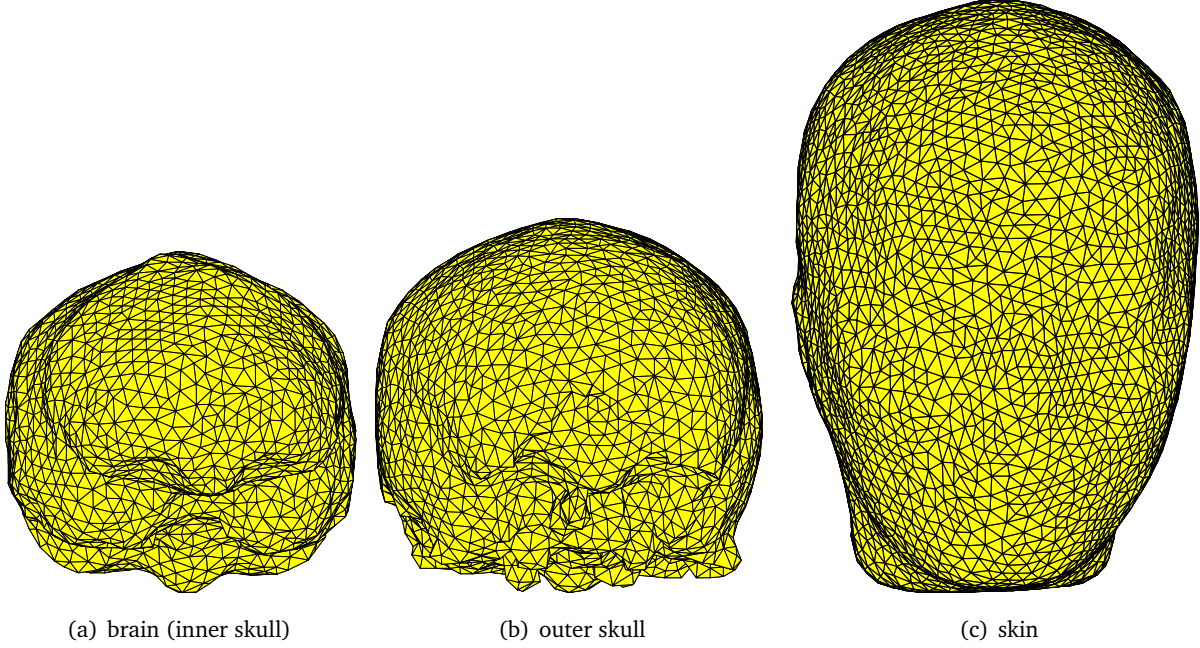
Three closed surface meshes extracted from CT and MRI (see chapter (ref)). a - approximation of brain or inner skull boundary, b - outer skull boundary, c - external head (skin) boundary.
